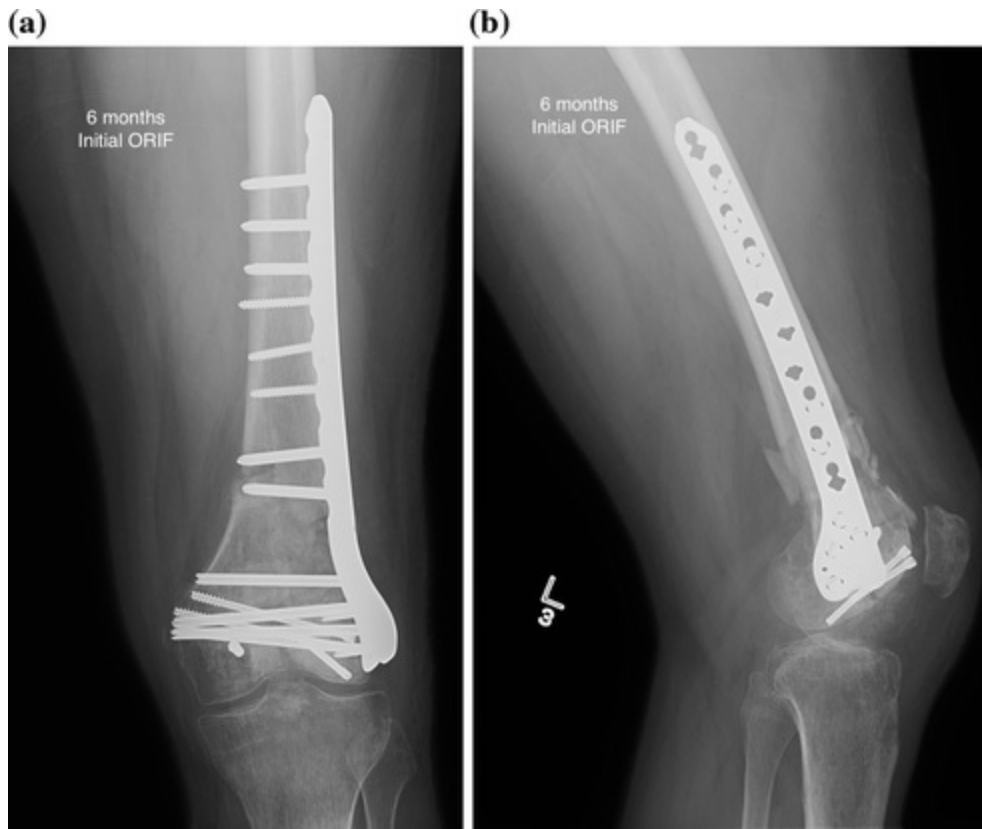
a Anteroposterior and b lateral left knee radiographs at 6 months. a There appears to be some consolidation at the medial cortex as well as in the metaphyseal region, but some subsidence of the plate is seen with collapse at the fracture site but stable hardware; b lateral shows increasing consolidation anteriorly
